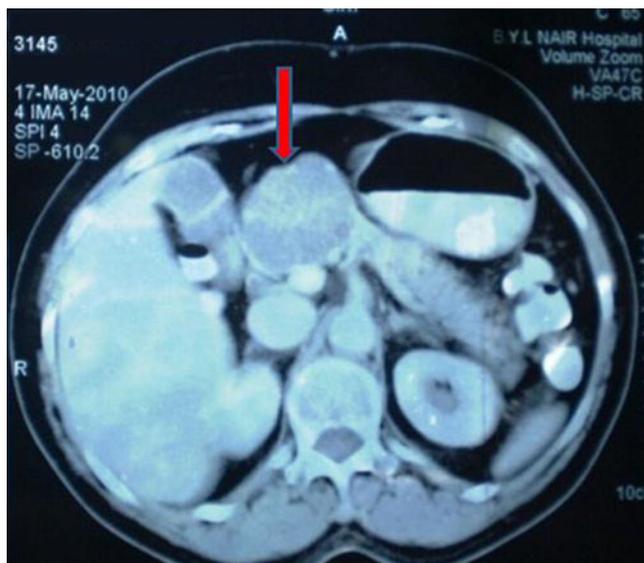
CT scan showing mass lesion in the head of pancreas (*arrow*)
